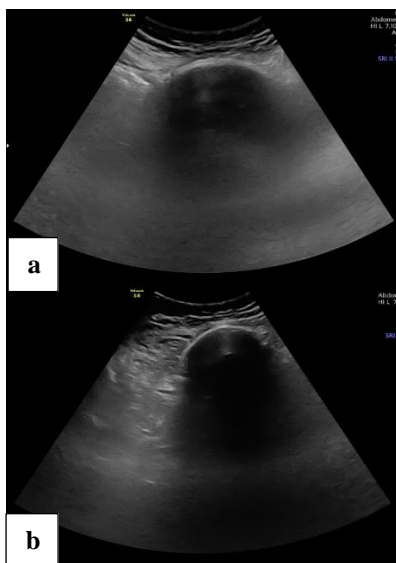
(a and b): Ultrasound pelvis reveals: a well-defined hypoechoic lesion with hyperechoic margin and significant posterior acoustic shadowing.
